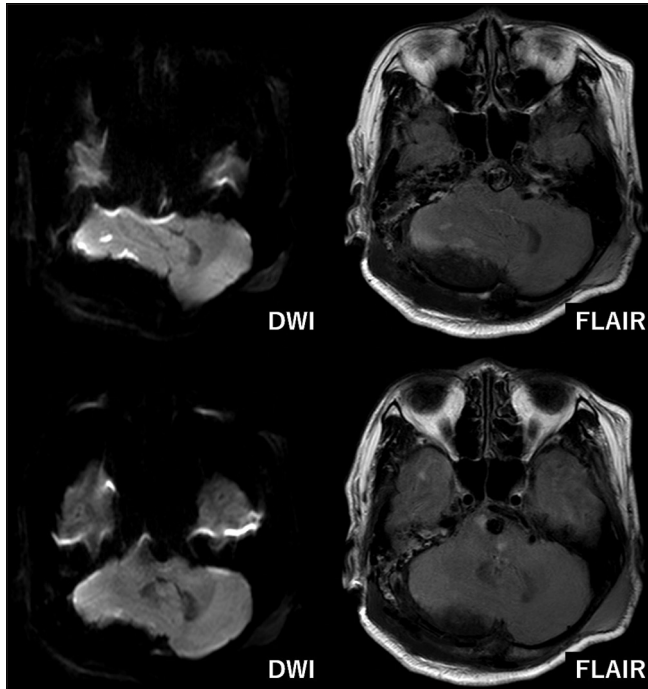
Postoperative magnetic resonance image showing sporadic cerebellar infarctions.
